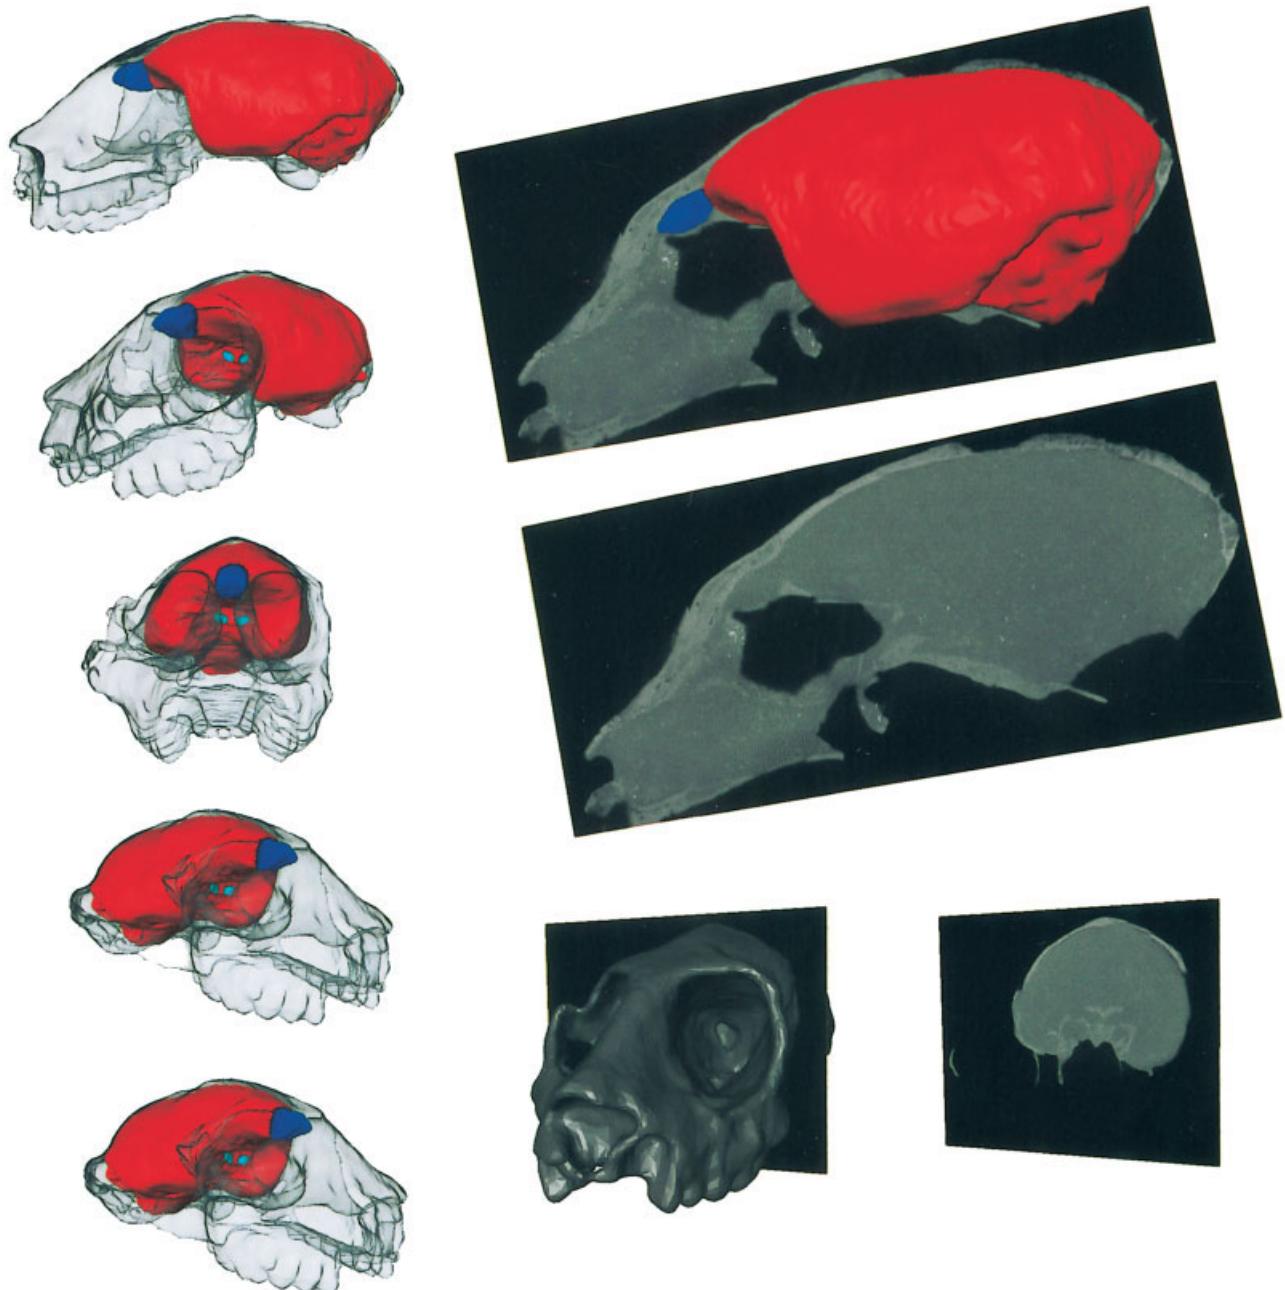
The column at the left is surfaces made from our CT data set. They show the endocranial cavity (red) along with the olfactory bulbs (dark blue) and the optic foramina (light blue). The surface of the skull is rendered transparent. At right, a sagittal slice through the data set reveals the olfactory bulbs, and a coronal slice through the optic foramina is also shown.
